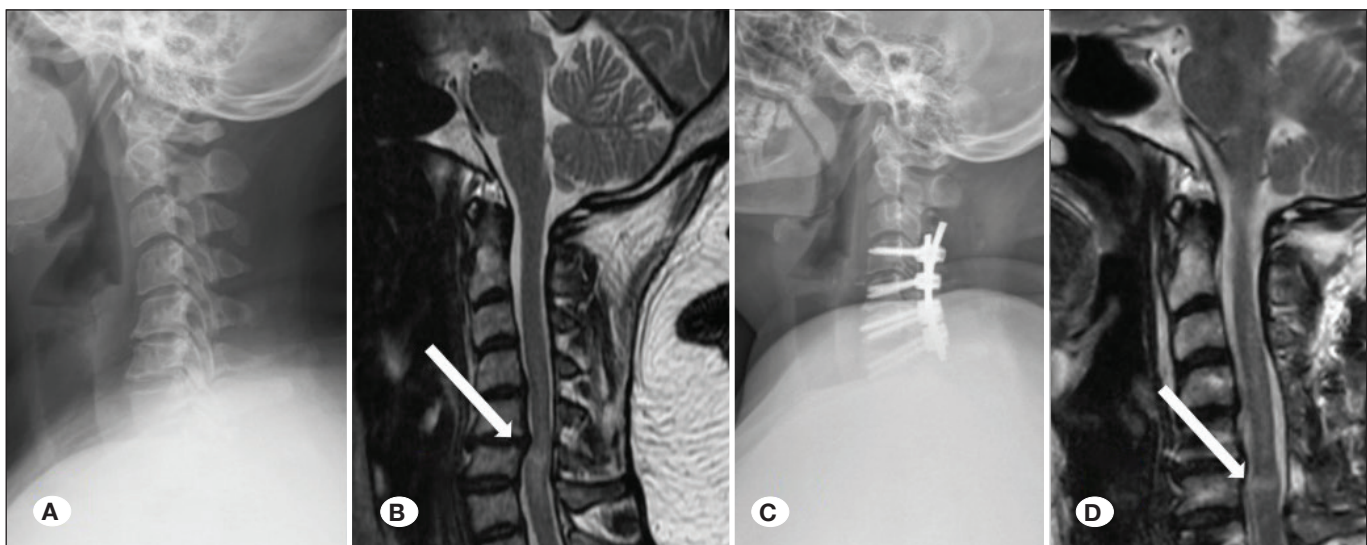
Patient images without ISI (latent) changes. A) Preoperative lateral cervical graph. B) White arrow indicates increased intensity of the medulla spinalis. C) Metallic surgical instruments applied to C4-7 levels are shown. D) On sagittal T2WI MRI, the white arrow shows an increase in intramedullary intensity, remaining latent.
